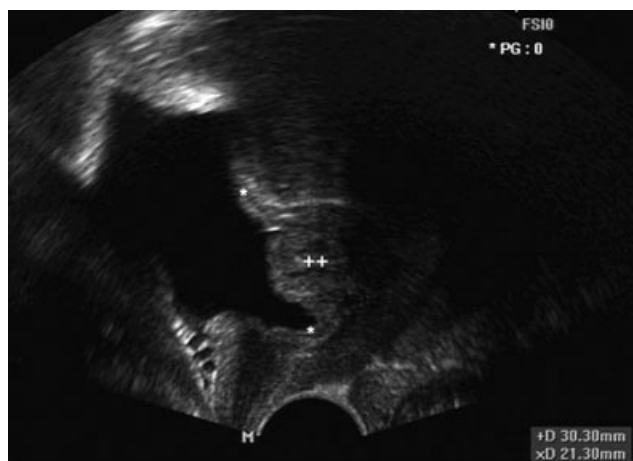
Transvaginal sonography showing a solid isoechogenic nodule (++) arising from the posterior wall of the urinary bladder (*), corresponding to deep infiltrating endometriosis of the bladder.
